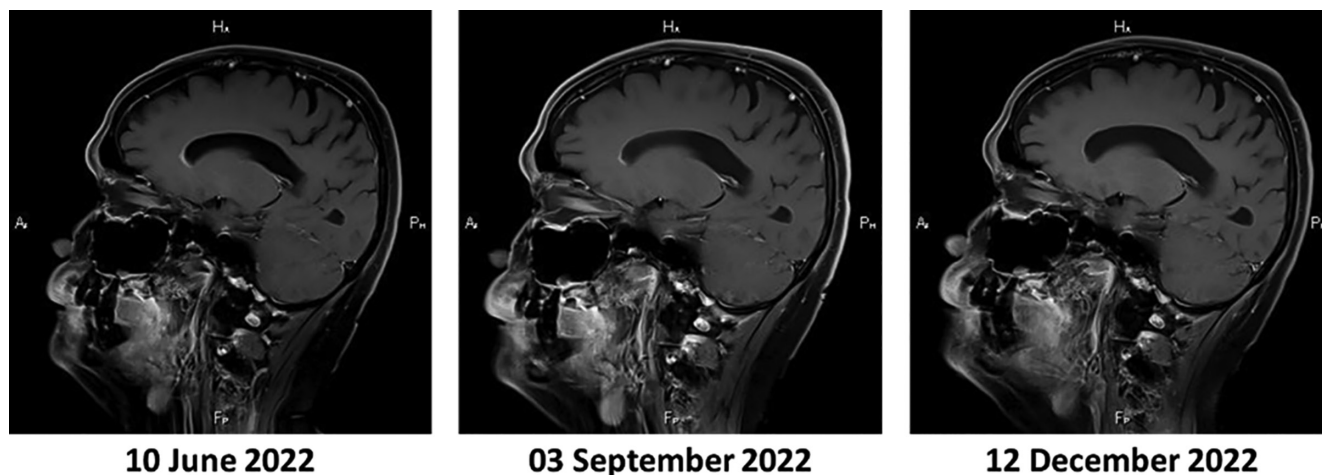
Brain MRI of patient and reduction of in size of nodule on MRI on 12 December 2022.
